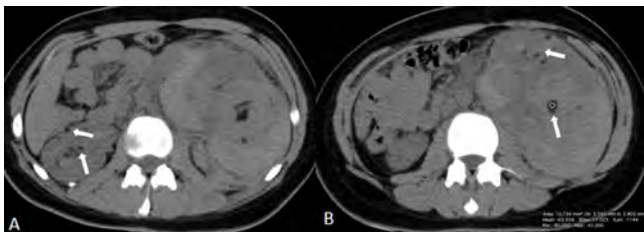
Non-enhanced CT scans at the bilateral kidneys show a low-density small lesions associated with a few interior fat components (arrows) and a hemorrhage presented spread into the left perirenal space (A,B).
